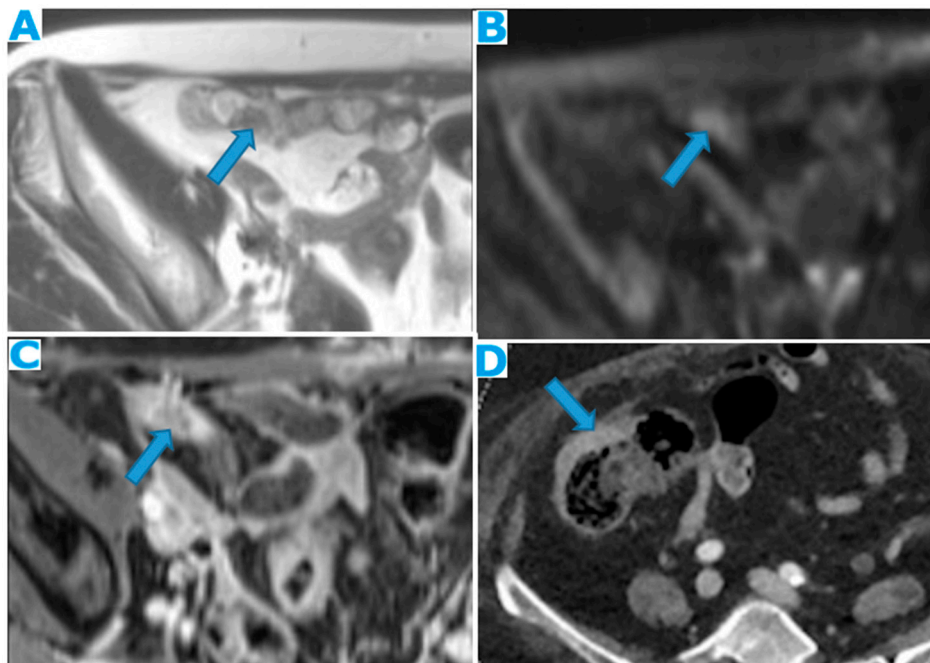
Axial T2WI (A), axial DWI (B), CE portal phase FST1WI (C). PC from duodenal adenocarcinoma: Deposit within the distal ileum serosa. Axial CE-CT (D). PC from breast carcinoma: Deposits within the caecal serosa.
